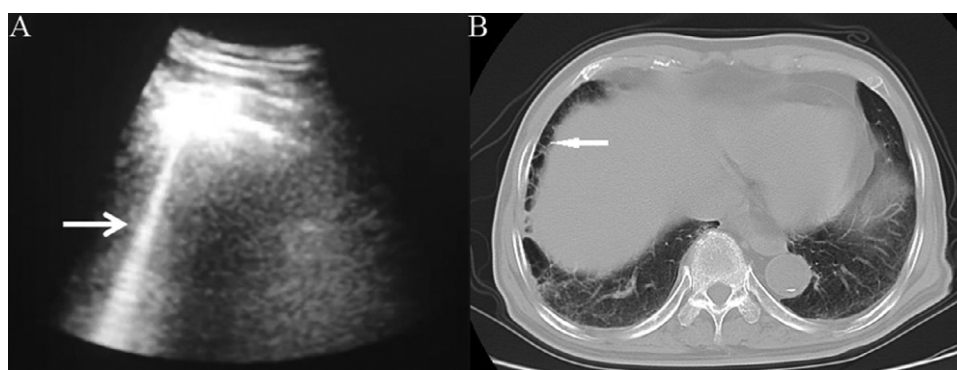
Sonographic and computed tomography (CT) images of pulmonary cyst in a severe COVID-19 patient, showing an Am line (*arrow*) on ultrasound (A) and cyst (*arrow*) on CT (B).
